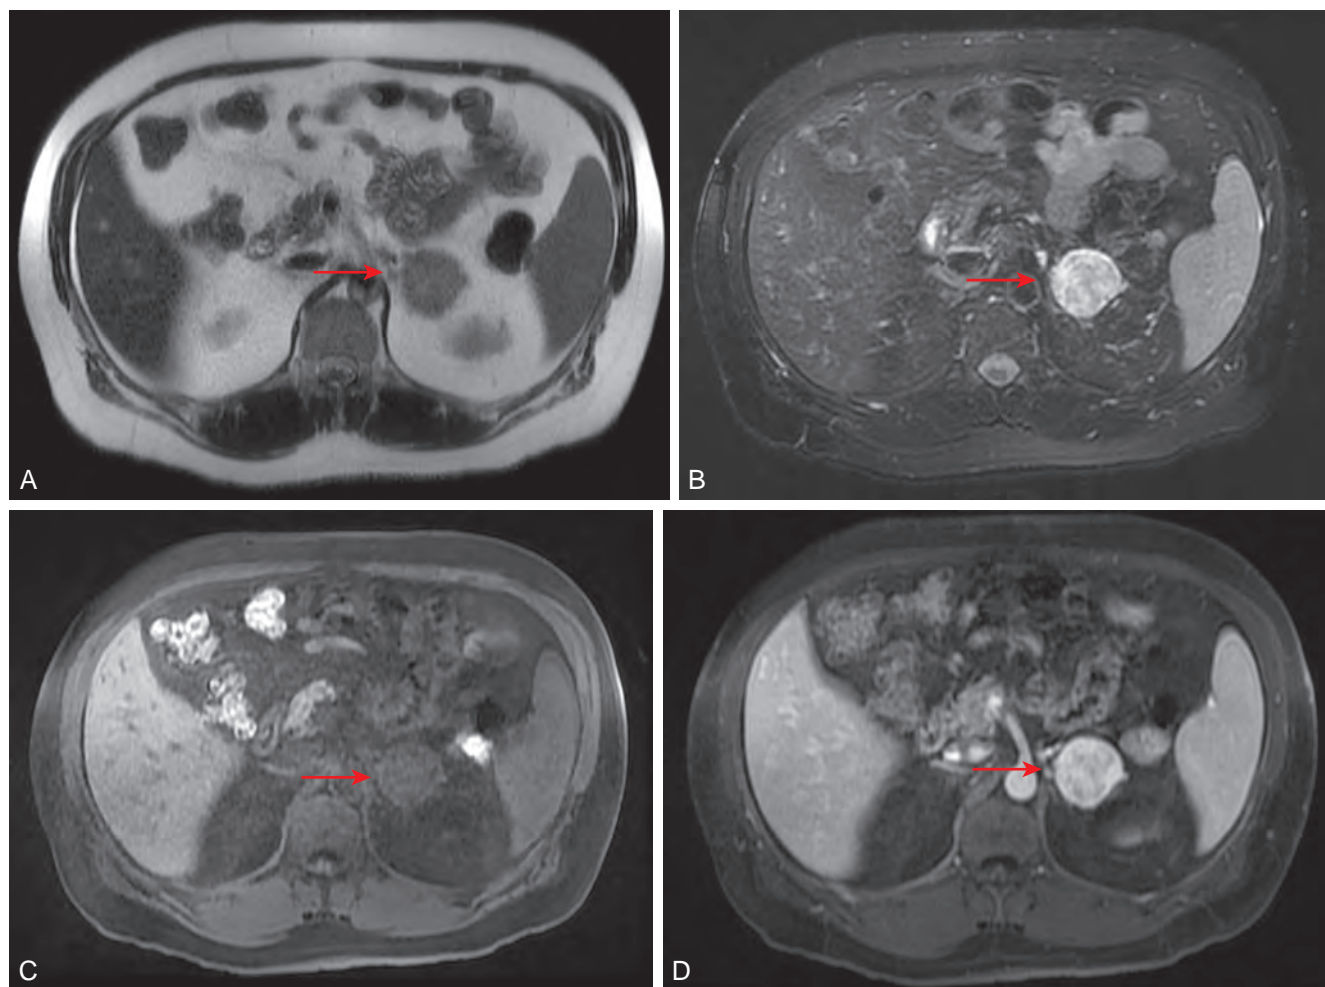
A 50-year-old man with a left side pheochromocytoma (as shown by arrows) and select images from 1.5-tesla magnetic resonance imaging. A, Heavily weighted T2 single-shot fast spin echo with an isointense signal (not bright). B, Moderately weighted T2 fat-suppressed, fast-recovery, fast spin echo with hyperintense signal (bright). C, T1-weighted precontrast image. D, T1-weighted postcontrast image with marked early enhancement.
